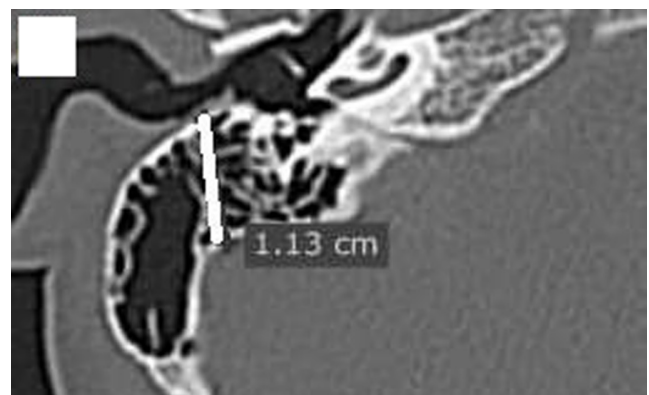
Axial cut of right temporal bone HRCT, showing the distance (11.3 mm) between the anterior edge of the sigmoid sinus and the posterior wall of the EAC, indicating the normal position of the sigmoid sinus (it was scored 0 marks). HRCT, high-resolution CT scan.
